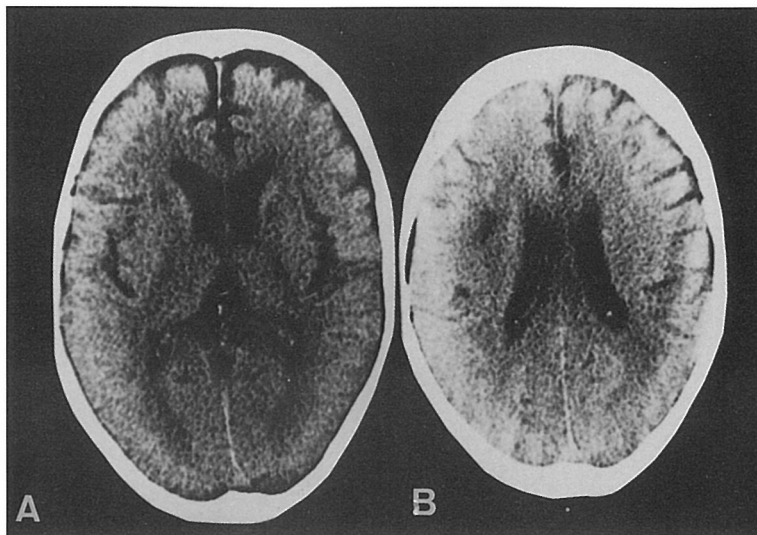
Computerized tomography (CT) scans in case 2. Plain CT (A and B) shows multiple lacunar infarcts in bilateral basal ganglia and in the left frontal white matter.
